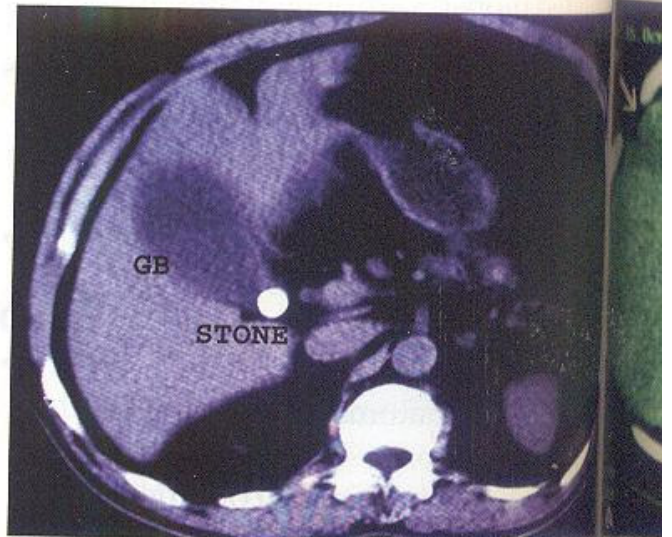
CT scan showing gallbladder stone in Hartmann's pouch causing obstruction.
